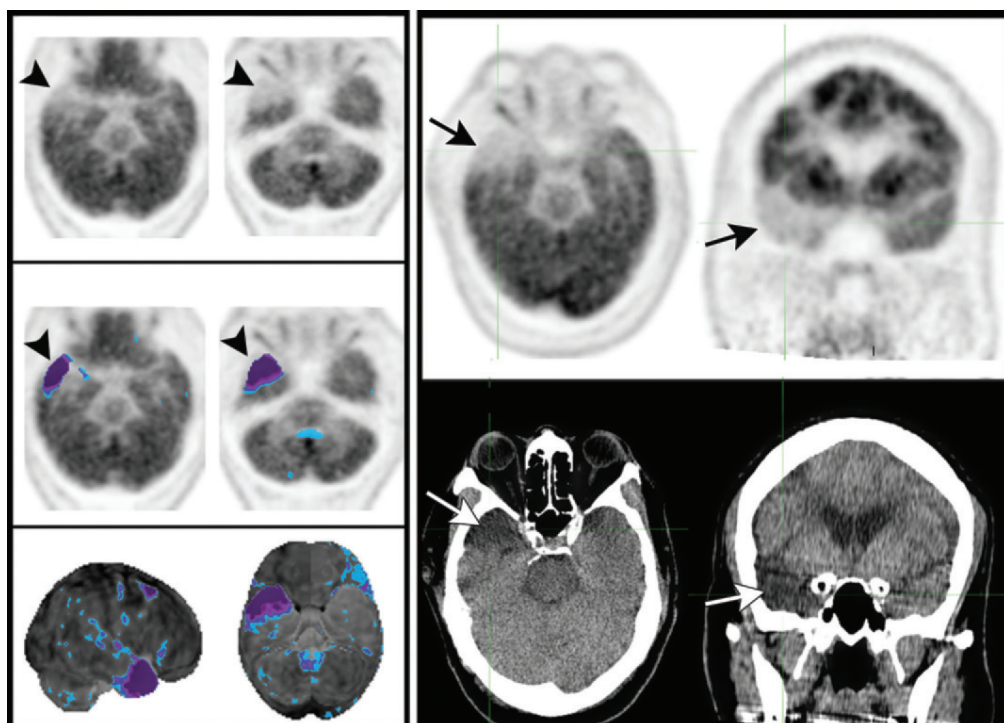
Arachnoid cyst. Axial gray-scale FDG PET images (top left), corresponding statistical thresholding overlay images (middle left), and 3D SSP images (bottom left) obtained in the right lateral (left) and inferior (right) projections demonstrate hypometabolism in the anterior aspect of the right temporal lobe (arrowheads). This finding may be misinterpreted as the semantic or temporal variant of FTD if the CT images are not reviewed. In this case, however, the finding is caused by an arachnoid cyst, not a neurodegenerative condition, as indicated by an arrow on axial and coronal PET images (top right) and axial and coronal coregistered CT images (bottom right). Z-score: blue = -2 SDs, purple = -3 SDs.
